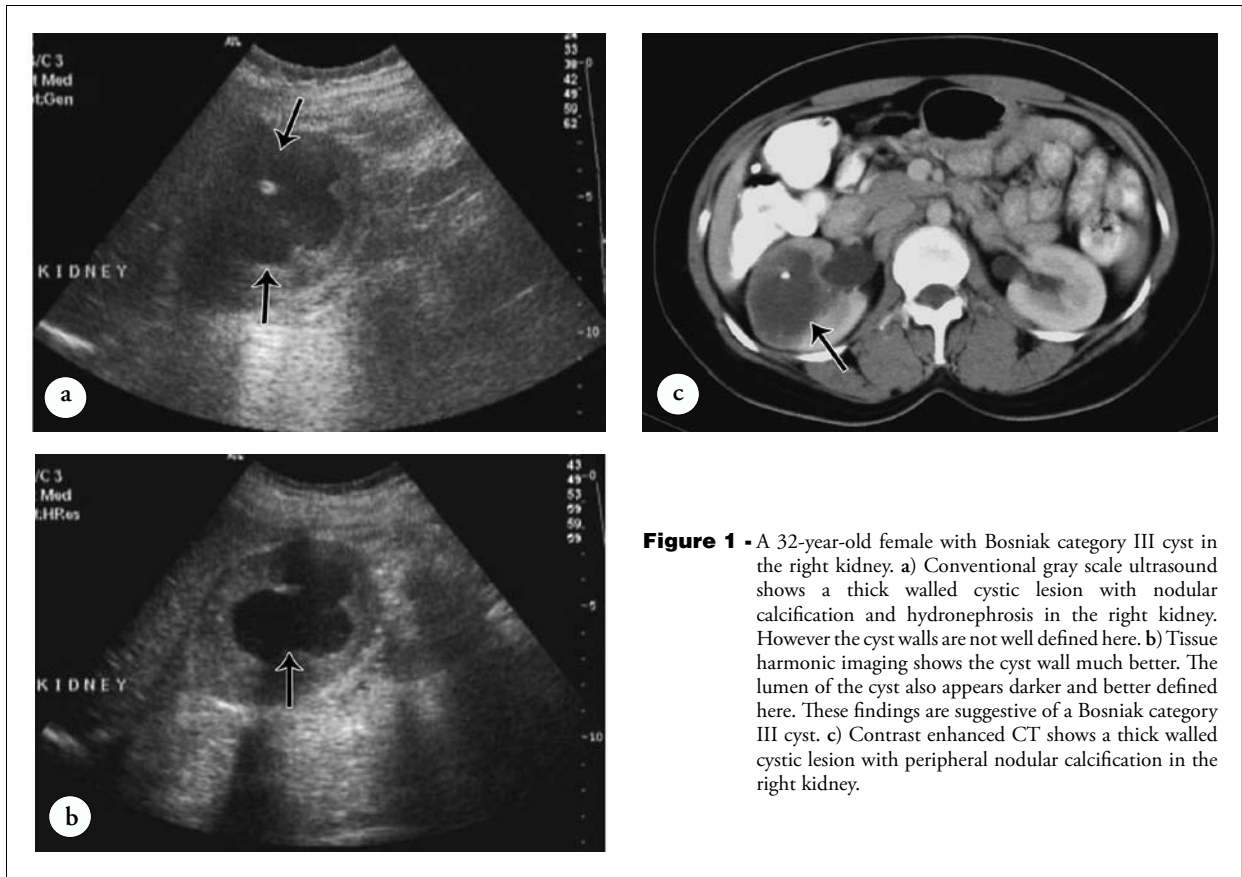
A 32-year-old female with Bosniak category III cyst in the right kidney. a) Conventional gray scale ultrasound shows a thick walled cystic lesion with nodular calcification and hydronephrosis in the right kidney. However the cyst walls are not well defined here. b) Tissue harmonic imaging shows the cyst wall much better. The lumen of the cyst also appears darker and better defined here. These findings are suggestive of a Bosniak category III cyst. c) Contrast enhanced CT shows a thick walled cystic lesion with peripheral nodular calcification in the right kidney.
